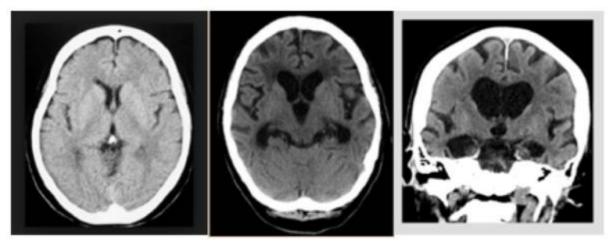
(a) CT scan of normal brain; (b) CT scan of early stage AD; (c) CT scan of late stage AD
